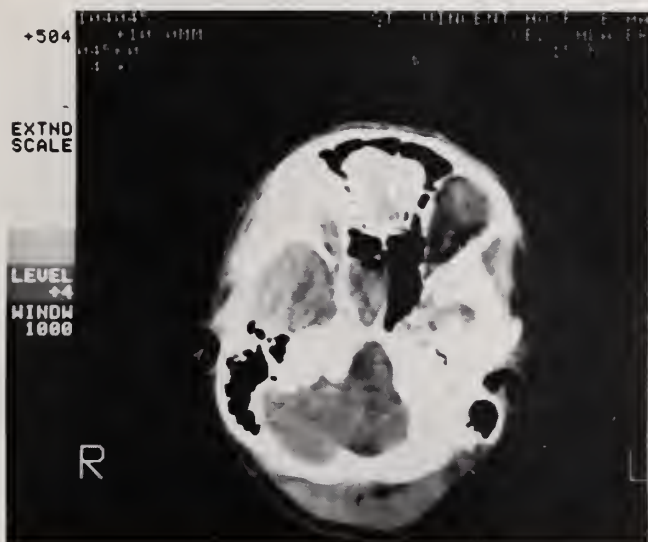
CT scan of Case #1, revealing opacification in the right sphenoid sinus.
